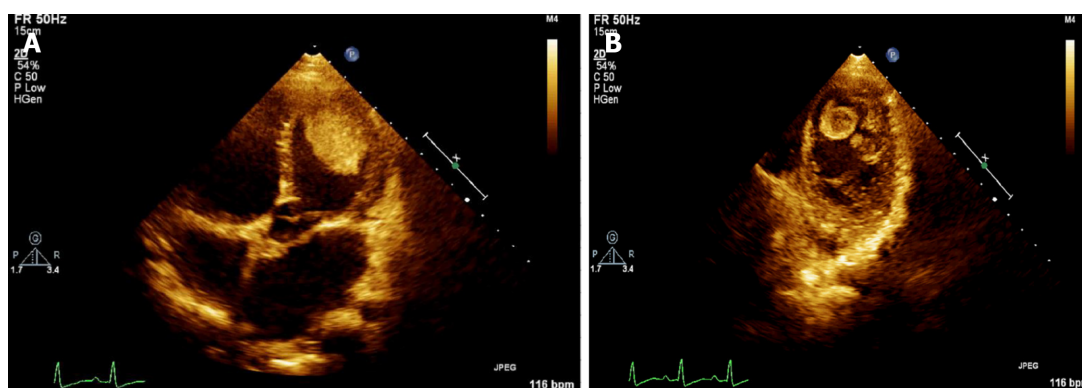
False color imaging of thrombi using two-dimensional echocardiography. A: Apical four-chamber view shows a large thrombus near the apex of the lateral wall of the left ventricle; B: Two thrombi were also detected at the apex of the left ventricle.
